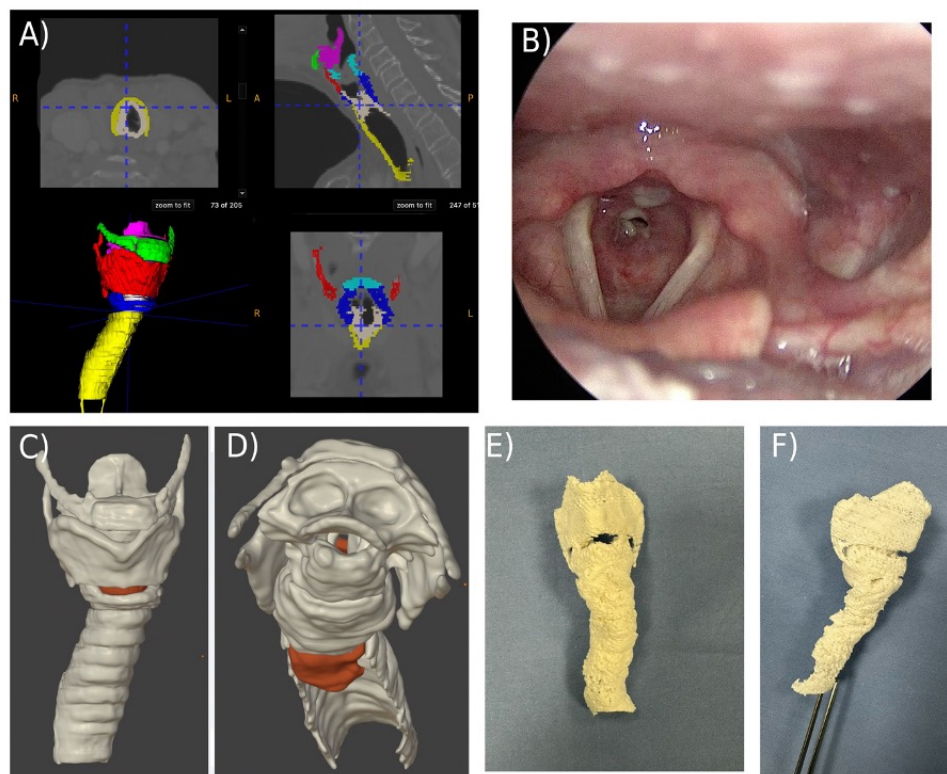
Steps and materials used during the creation of the preoperative 3D model in *Case 2*. A – The preoperative CT image and the segmentation process are shown. Color legend: green – hyoid bone; red – thyroid cartilage; dark blue – cricoid cartilage; light blue – glottis; violet – epiglottis; yellow – trachea; grey – stenosis. B – A preoperative endoscopic image of the Cotton-Myers III grade subglottic stenosis. C, D – Refined virtual model after segmentation, frontal and superior view. Stenosis is indicated with the orange color. E, F – MEX printed models of *Case 2*, frontal and side views.
